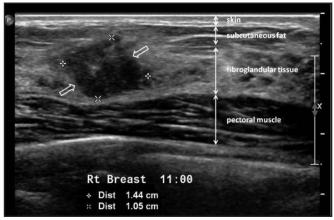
Ultrasound of the breast of the same patient as in Fig. 5 revealed an irregular, inhomogenous, hypoechoic nodule (block arrows). Percutaneous biopsy with ultrasound guidance revealed infiltrating ductal carcinoma. Notice that the ultrasound image clearly showed the different layers of breast tissue.
